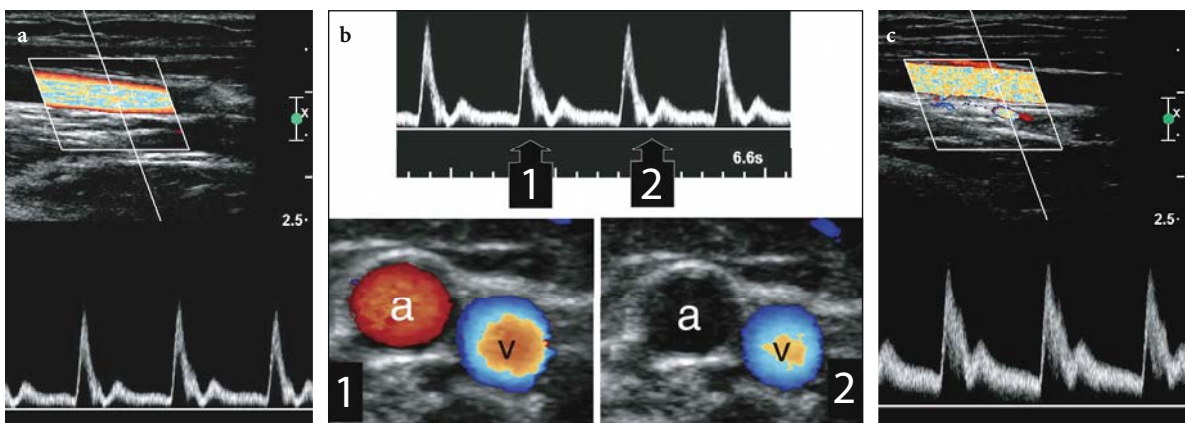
Normal Doppler imaging findings in the brachial artery. a Pulsed Doppler analysis shows normal high-resistance pulsatile flow with oscillations in diastole. A steered color box is used to obtain an adequate Doppler angle and clear-cut Doppler tracings. b Color Doppler imaging appearance of flow in the high-resistance brachial artery (*a*). There is evidence of color flow signal in systole (1) but not in the early diastolic phase (2). Continuous blood flow is detected in the adjacent brachial vein (*v*) with complete filling of the vessel lumen, indicative of patency. c Following repeated fist clenching, the resulting vasodilation produces a higher forward flow throughout the cardiac cycle, particularly in diastole
